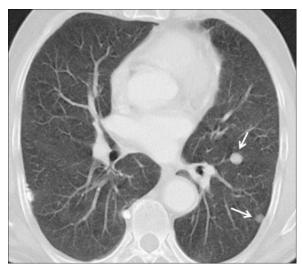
Computed tomography showing the multiple metastatic nodules in the lung.
